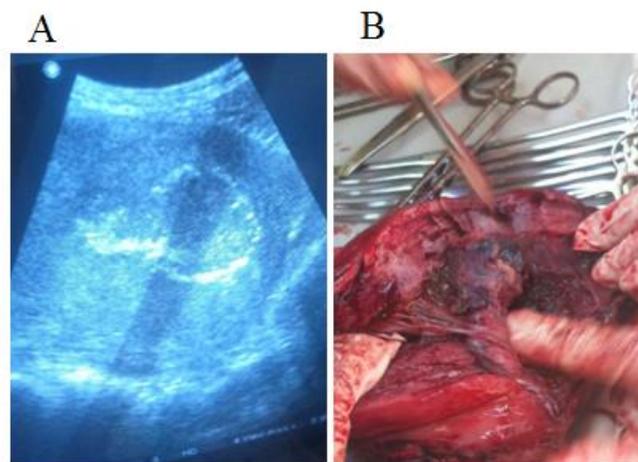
The hysterectomy piece for placenta accreta (A); The ultrasound before the intervention (B)
